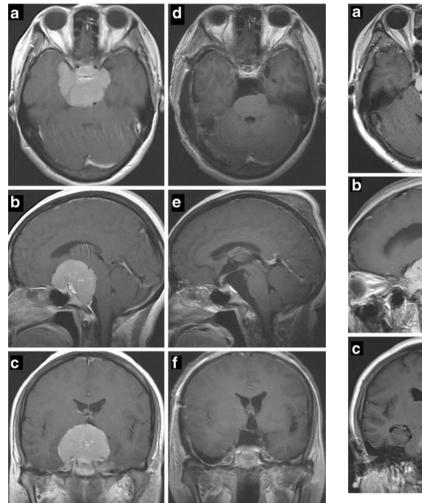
Case 3: pre- (a–c) and post-operative (d–f) magnetic resonance imaging. A 41-year-old female with a preoperative KPS score of 80. Tumor size was  $4.9 \times 5.5 \times 5.4$  cm. The anterior transpetrosal approach was performed, and the tumor was completely resected. The patient's postoperative, new-onset dysfunctions were oculomotor palsy, diplopia, and right eye ptosis, with a KPS score of 70 at discharge. The ptosis resolved 6 months after the operation. At the 51-month follow-up, she could work full time and experienced mild diplopia, which did not disturb her. Her most recent KPS score was 90, without tumor recurrence. *KPS* Karnofsky Performance Scale
